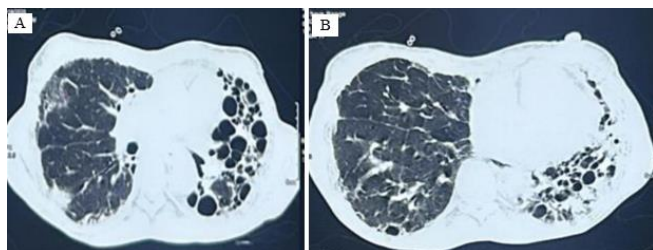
A,B: HRCT Chest :Chronic interstitial lung disease with interlobular and intralobular interstitial thickening, fibrosis, bronchiectatic changes, honeycombing, volume loss in the left lung involving upper lobe, lingula and lower lobe and interlobular and intralobular interstitial thickening, subpleural fibrosis with early honey combing noted subpleural aspect upper lobe right middle lobe and right lower lobe suggestive interstitial lung disease likely UIP pattern
